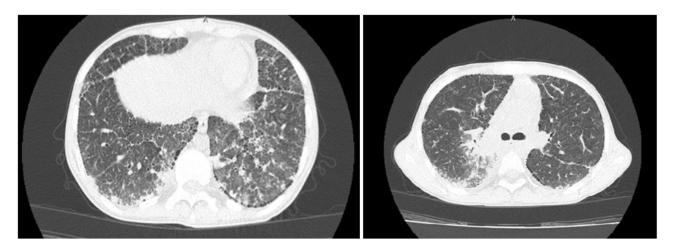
Computed tomography (CT) scan of the patient's lung showed interstitial lung disease (ILD) that caused severe scars of lung.
